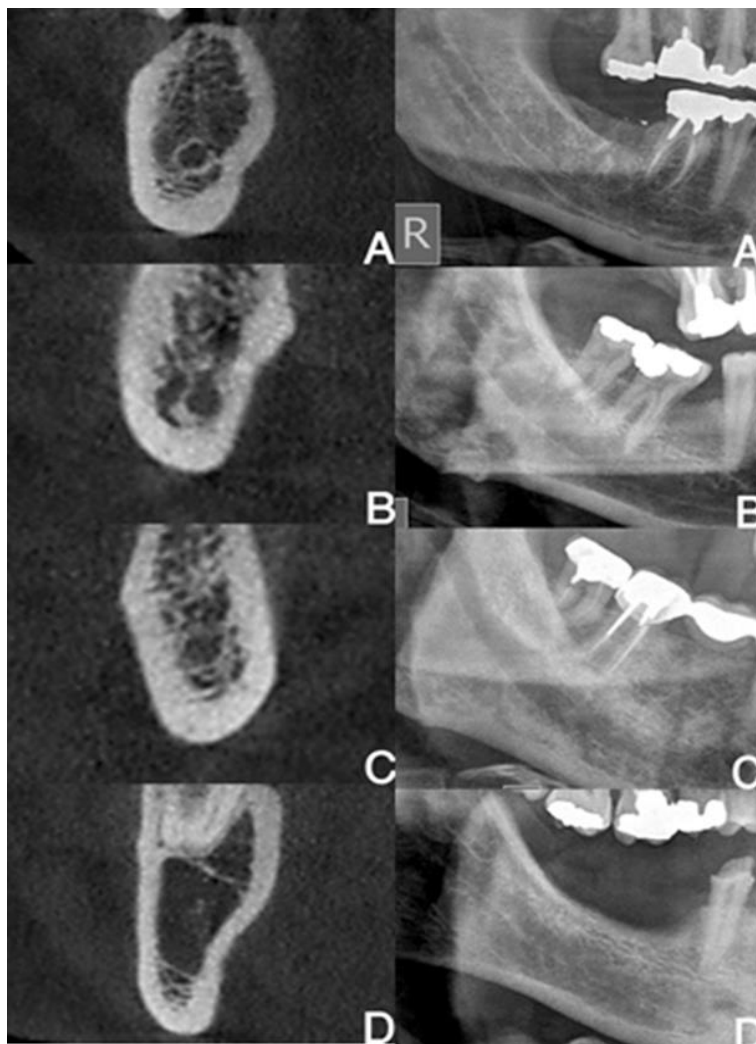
Comparison of grading of canal visibility in panoramic (right) and CBCT (left) images. A: Visibility of the upper and lower wall as cortical, B: Visibility of the lower wall of the canal as cortical, C: The boundary of the canal is visible but is not cortical, D: The canal is not visible.
